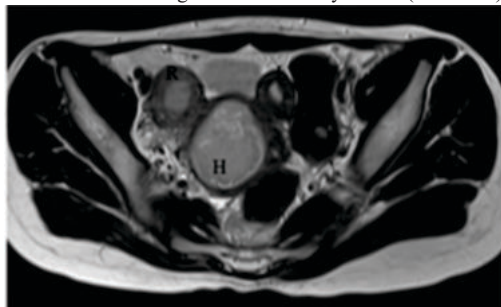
Non contrast axial T2 weighted MRI revealed two separate uterine horns (Right horn – R; Left horn – L; H- hematometocolpos)
